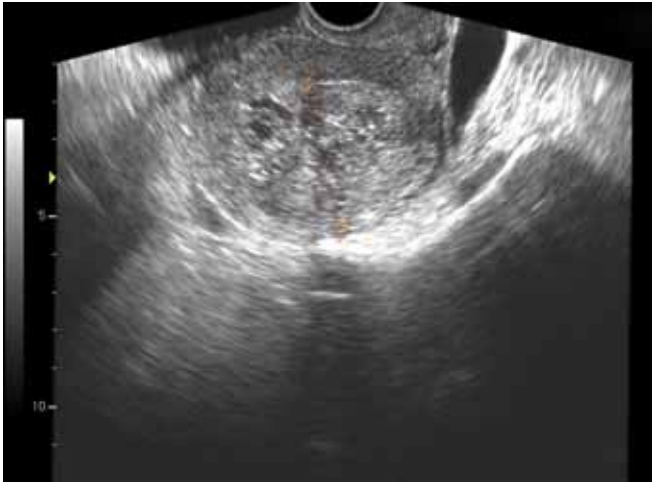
Transvaginal sonography of the case of CCE
